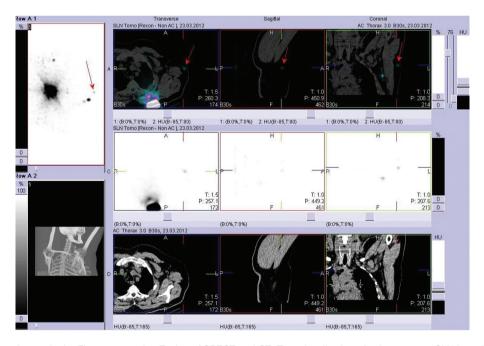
The same patient as in the Figure 1, 2 and 3. Fusion of SPECT and CT. Exact localization of subcutaneous SLN lateral to left axilla
